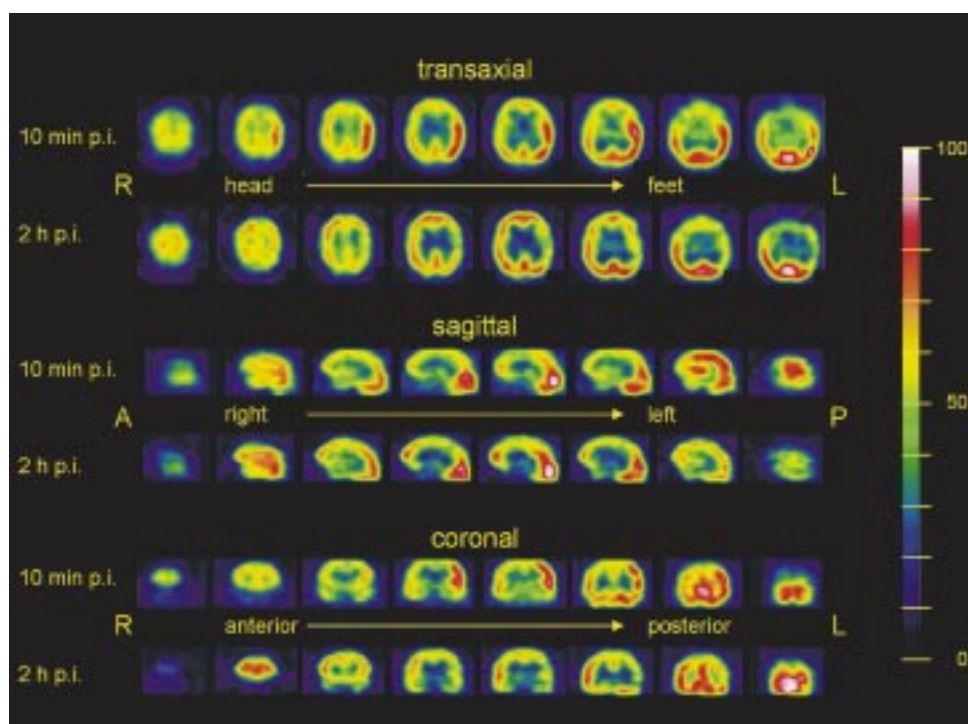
64-year-old patient with complete infarction of the left medial cerebral artery 10 days earlier. SPECT images were obtained 10 minutes and 2 hours after the injection of 200 MBq ^{123}I -iomazenil. Note the increased (luxury) perfusion in the left parietal cortex in the early images and a corresponding decrease of benzodiazepine receptor density in the late images. Thus, damage of cortical integrity was proved in the left parietal area.
